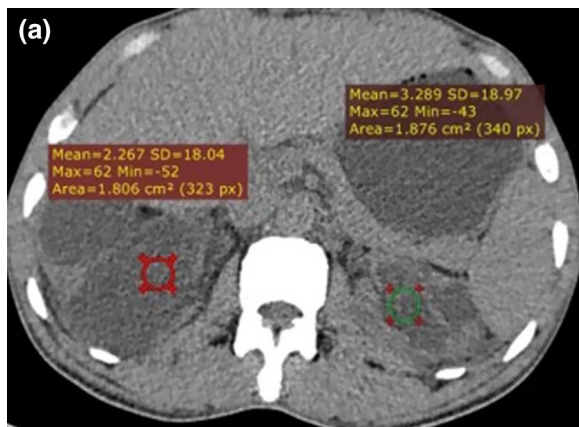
a CT scan showing markedly dilated both pelvicalyceal system and ureters with thinning out of the renal parenchyma. Mean HU within the dilated right pelvicalyceal system = 2.2 indicating the diagnosis of hydronephrosis. Mean HU within the dilated left pelvicalyceal system = 3.2 indicating the diagnosis of hydronephrosis. b Axial CT scan of the same patient showing bilateral pelvic renal stones
